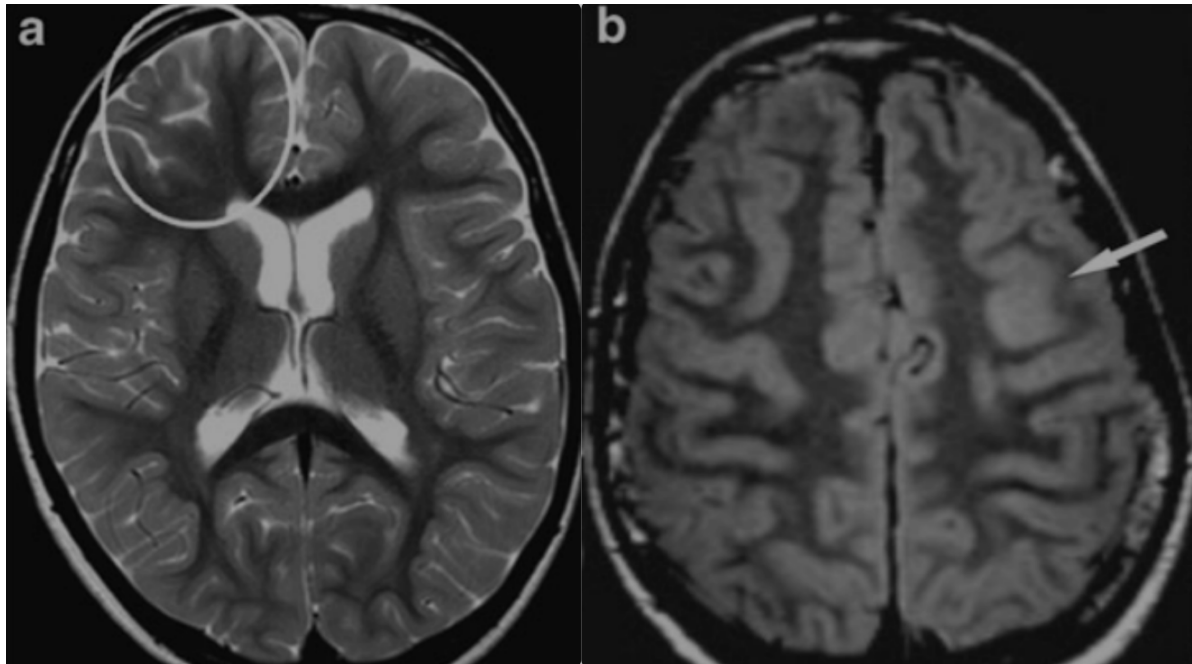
FCD type IIA (a) and FCD type IIB (b) in T2 and FLAIR scans respectively. Adapted from (45).
